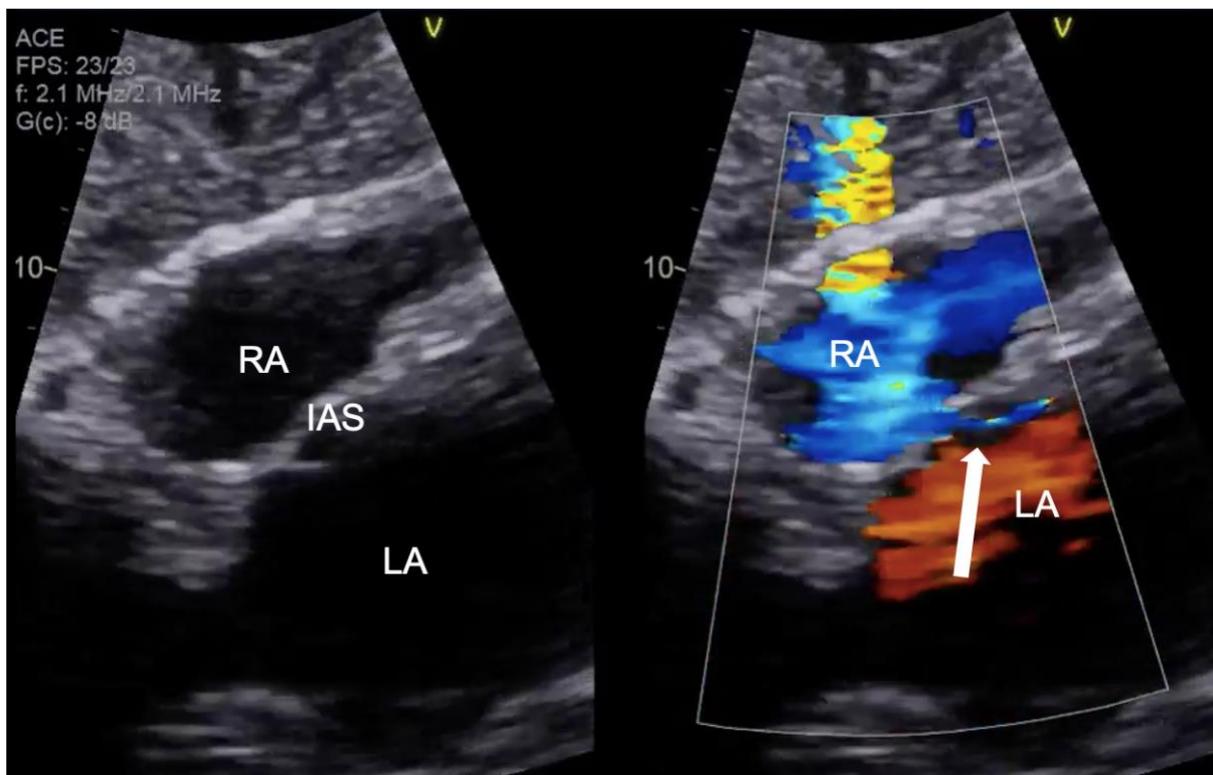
Subcostal view using TTE of the IAS, where venous blood (blue) can be seen travelling from the RA into the LA, and mixing with arterial blood (red). Abbreviations: TTE = transthoracic echocardiography, IAS = interatrial septum, RA = right atrium, LA = left atrium
